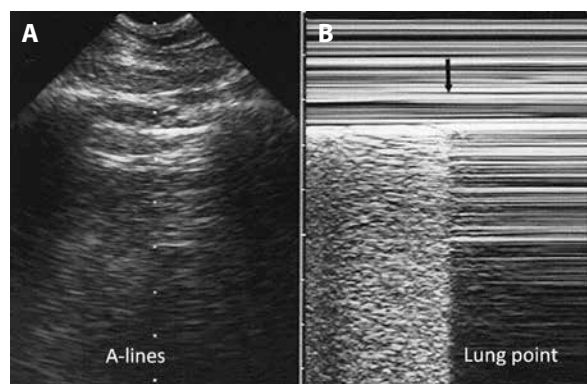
Pneumothorax at the lung point; A — real-time mode allows detection of the inspiratory increase in volume of the collapsed lung. When reaching the chest wall where the probe is positioned, it makes a sudden change in the ultrasound image, usually from an A'-profile to an A- or B-profile. The change is sudden because ultrasound is a highly sensitive method, able to detect subtle changes, such as the difference between free gas and alveolar gas; B — M-mode. The left-hand side of the image shows lung patterns (lung sliding) before the visceral pleura disappears. The arrow shows the exact moment the visceral pleura is no longer in contact with the pleura line. The right-hand side image shows the A'-profile (lung sliding abolished with A-lines). This sign has been called lung point, a specific sign of pneumothorax. Adapted from 'Lung ultrasound in the critically ill' [11]
